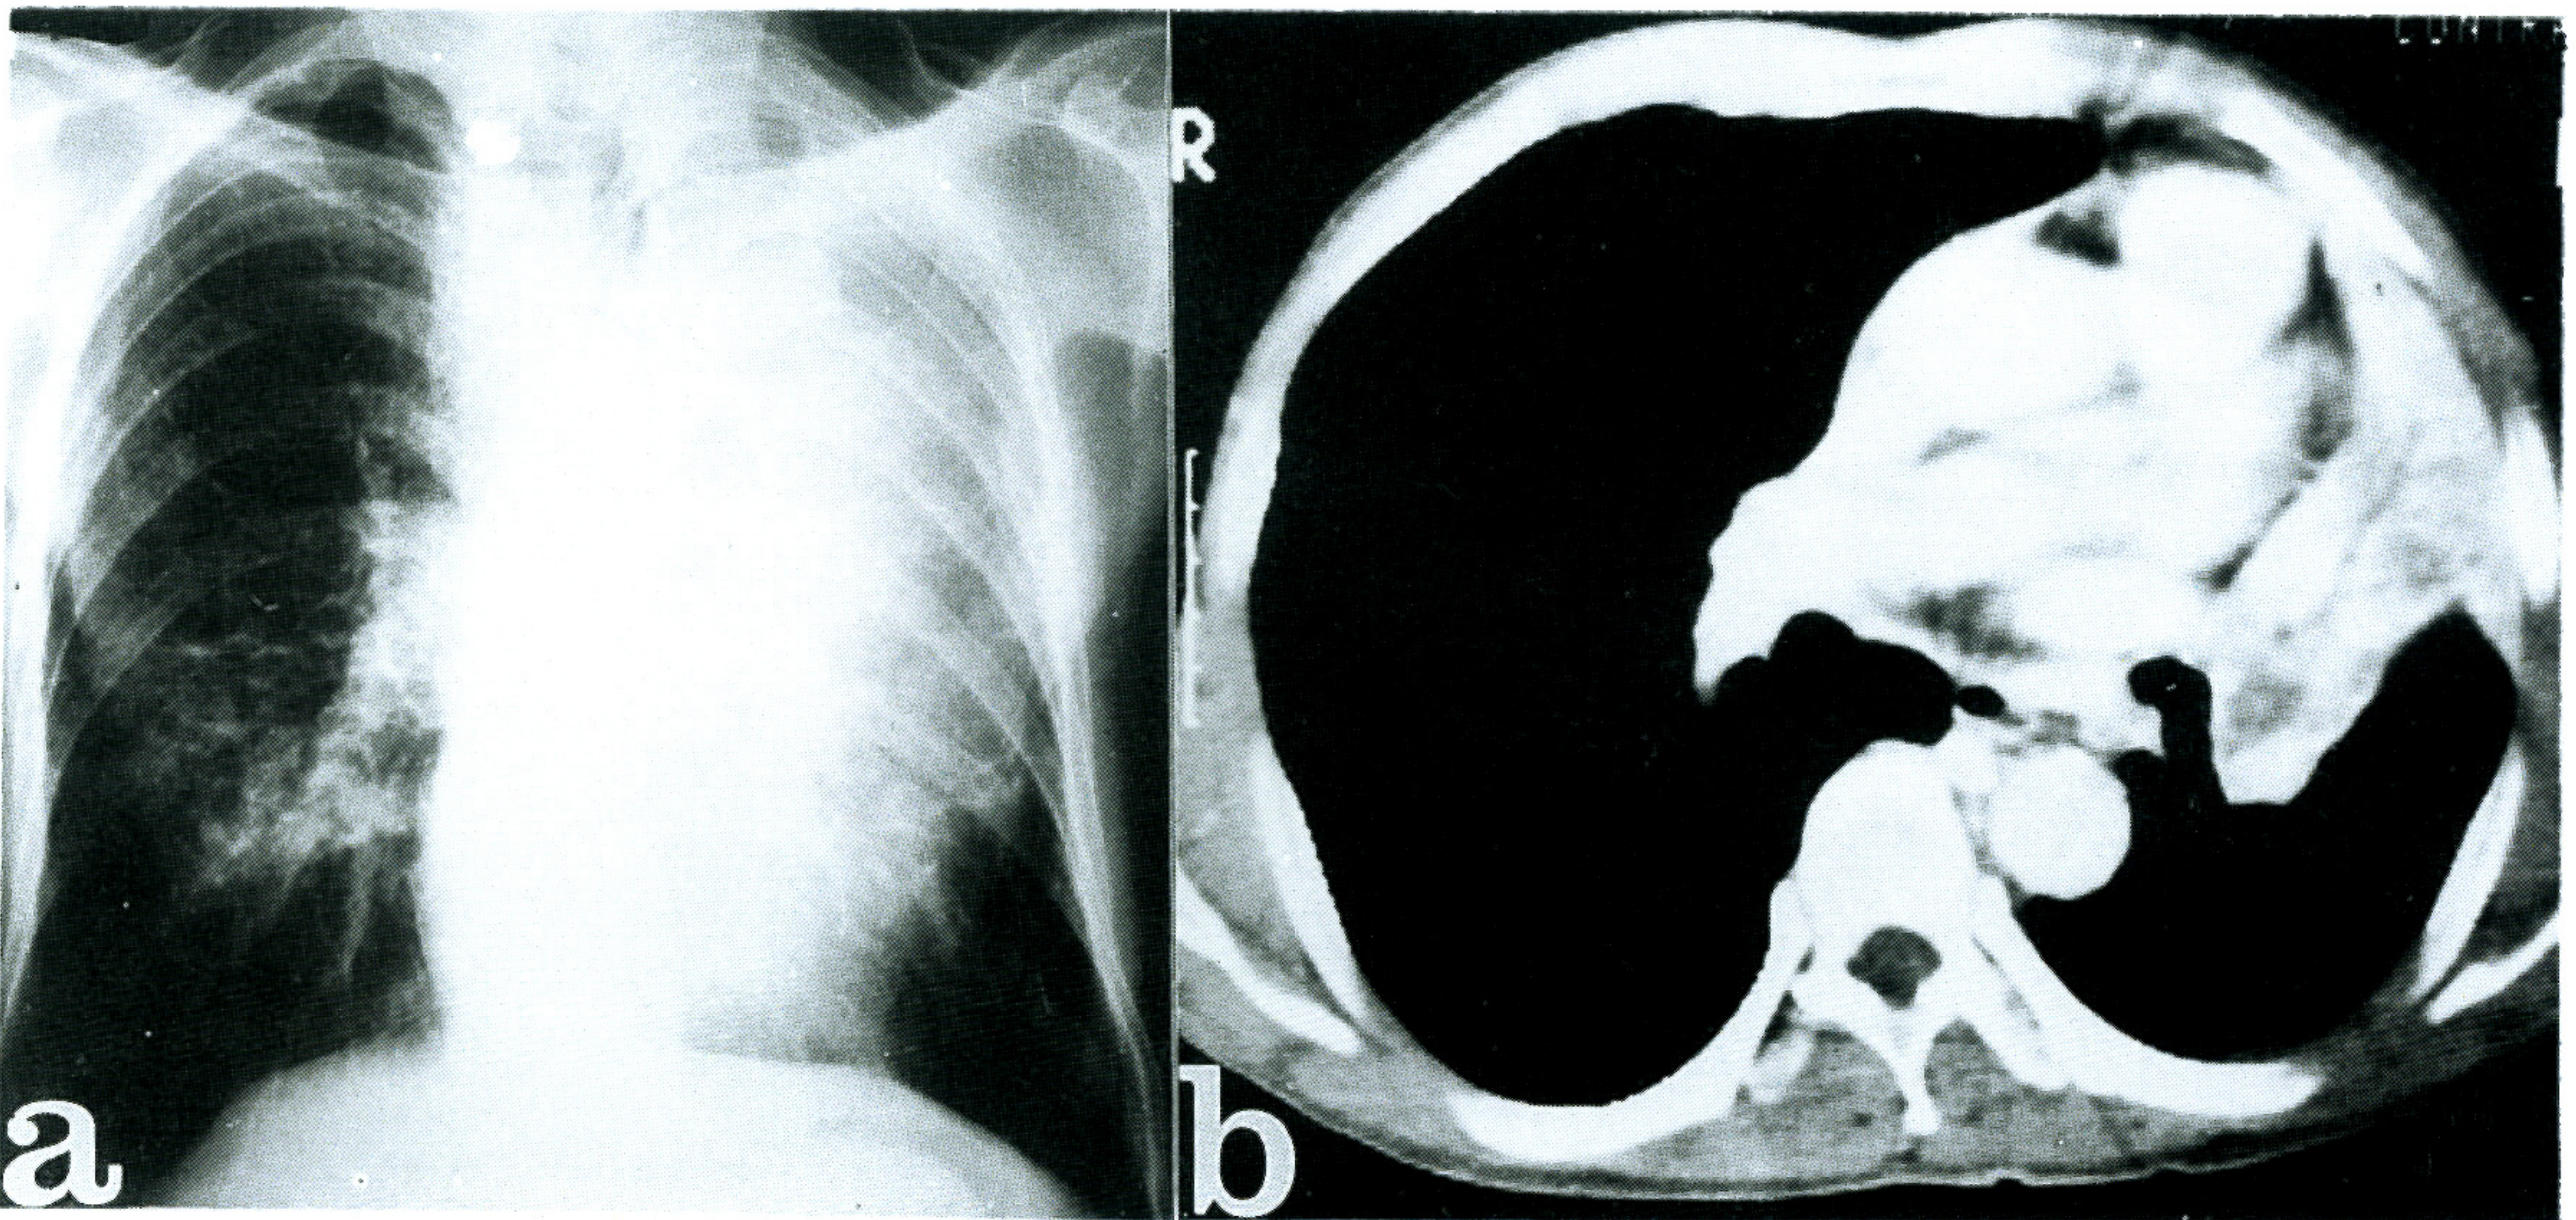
An X-ray film of the chest shows the ill-defined left perihilar haziness with peripheral infiltration (3a). The chest CT scan shows an about 4cm sized elliptical left hilar mass involving the left main bronchus and the upper lobe bronchi with the left anterior mediastinal metastatic lymph nodes and collapsed, consolidated left upper lobe (3b).
